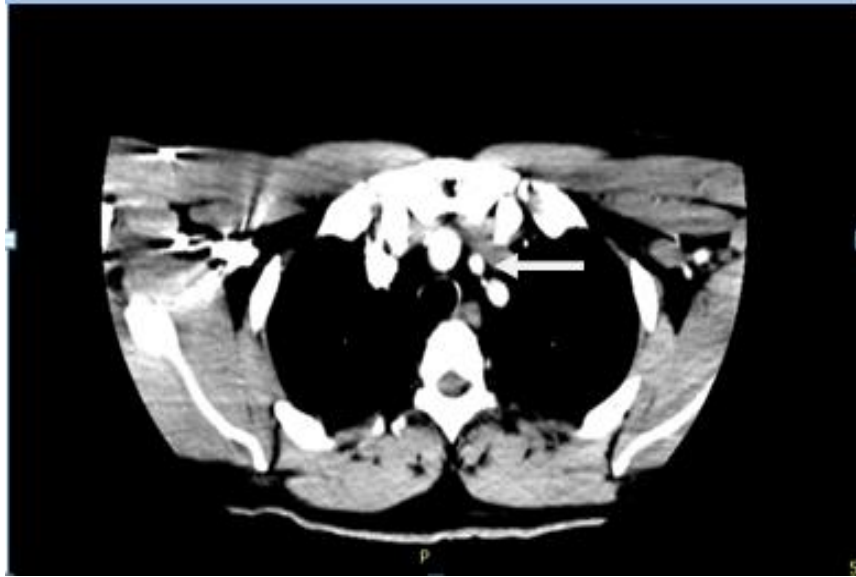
Left aortic VA origin in axial CTA
